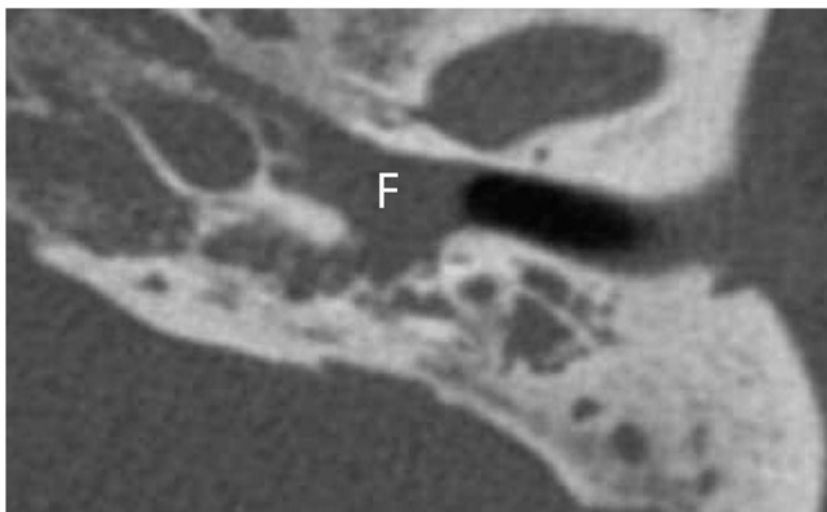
CT image (horizontal plane, right ear). Extension of MMF to the tympanic cavity.
